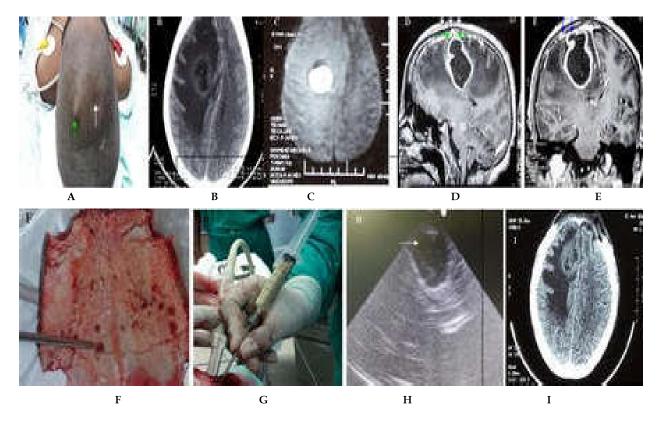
Clinical photograph of patient showing paramedian scalp mass behind coronal suture on left (green arrow) and discharging sinus on right (orange arrow). B: NCCT head showing hypopdense circumscribed right frontal lesion with disproportionate perilesional edema. C: DWI MRI imaging showing diffuse restriction of the lesion. D: Gadolinuim enhanced T1W saggital images showing hypodense lesion with regularly enhancing wall just posterior to coronal suture. Green arrow depicts the fistulous tract extending from skin to dura and orange arrow shows osteomyelitis of frontal bone. E: Gadolinium enhanced T1W coronal images showing abscess cavity with dural enhancement. Also seen are the frontal bone osteomyelitic changes and subperisoteal abscess formation (blue arrow) F: Intraoperative photograph of the bone showing changes of osteomyelitis. G: Ultrasound guided aspiration of pus using brain needle. H: Use of ultrasound to localize the lesion and assist in real time evacuation of abscess cavity. I: Post operative CT scan showing no residual abscess cavity
